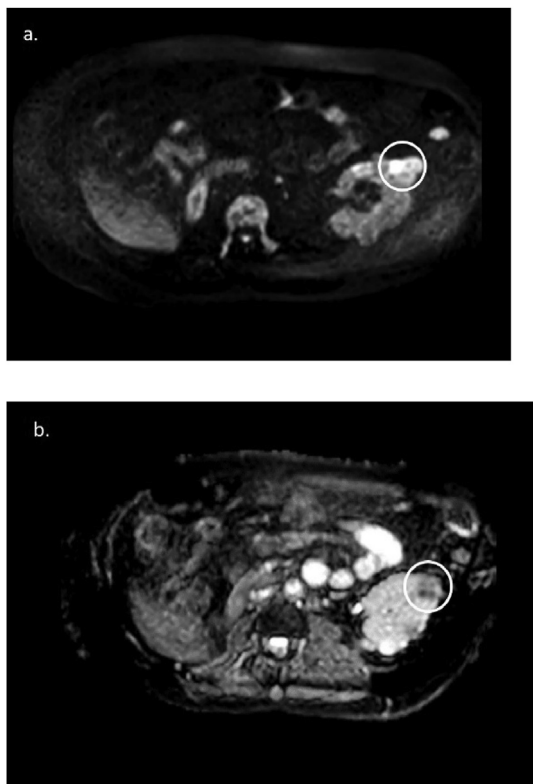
Renal cell carcinoma of left kidney, (a) hyperintense on DWI, (b) hypointense on ADC.
